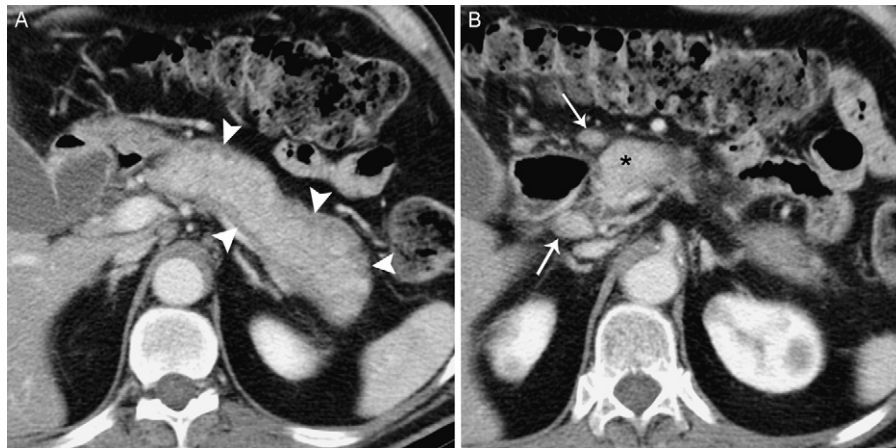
(A) Transverse, contrast-enhanced CT image of the upper abdomen shows diffuse enlargement of the pancreas with a peripheral rim of low attenuation (arrowheads), the characteristic finding in autoimmune pancreatitis. There is no stranding of the peripancreatic fat. (B) Transverse image at the level of the uncinate process (asterisk) shows enlarged peripancreatic lymph nodes (arrows).
